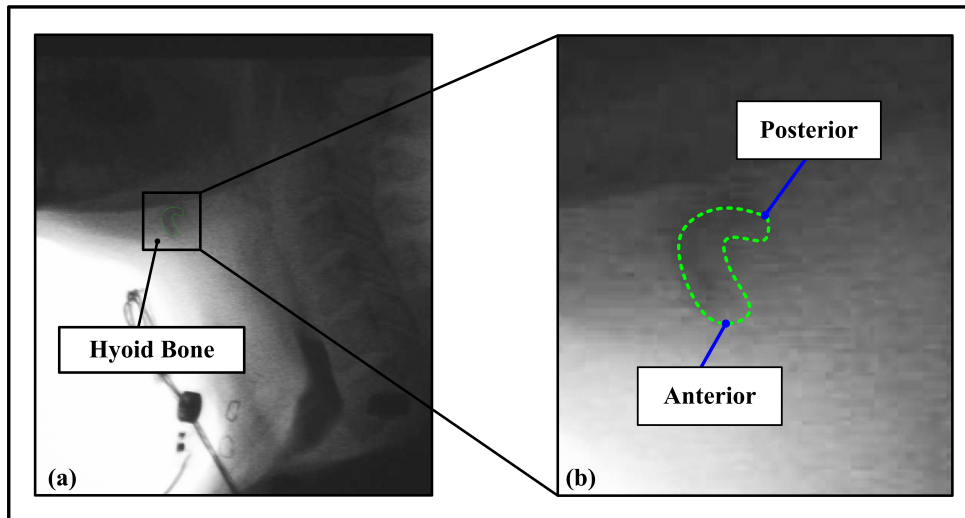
Hyoid bone and tracking points. Green dotted line marks the outline of hyoid bone to improve visibility (a) X-ray image of hyoid bone, (b) Posterior and anterior points for tracking.
